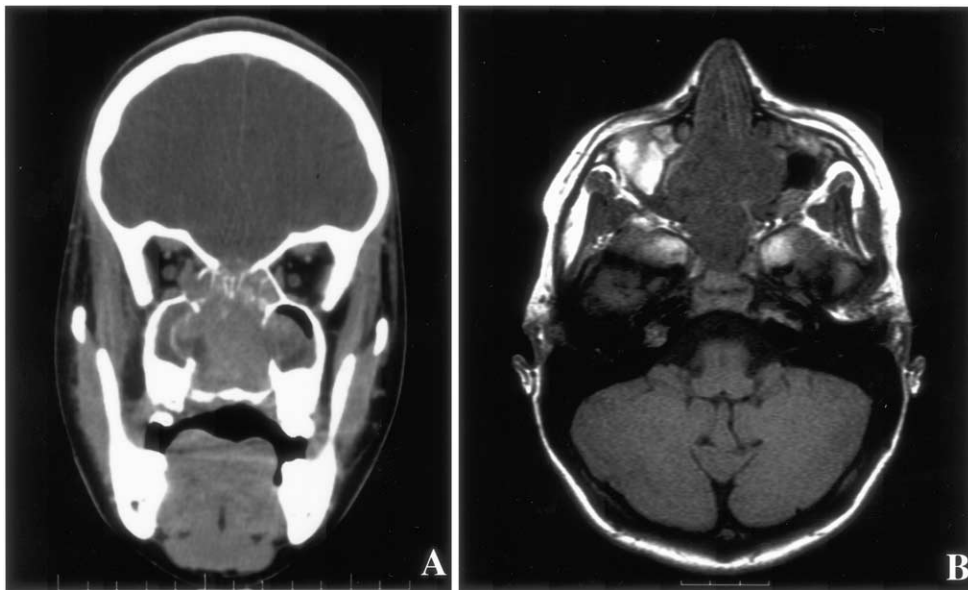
A, Coronal contrast-enhanced CT demonstrates heterogeneously enhancing tumor filling the nasal cavity with erosion of the medial walls of the maxillary antra and extension through the anterior cranial fossa. Obstructed secretions are present in the paranasal sinuses. B, axial T1-weighted MR image without contrast reveals the extensive sinonasal tumor.
